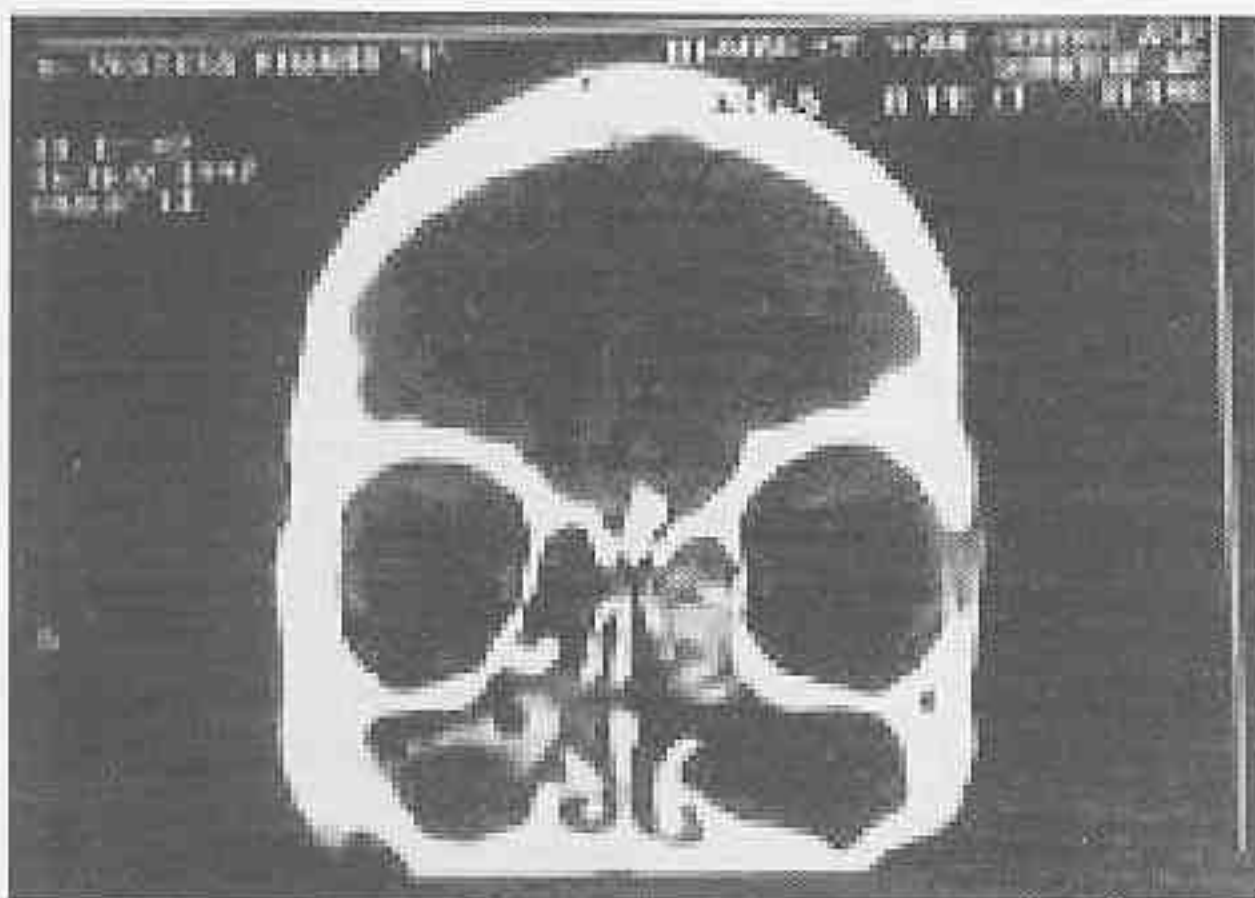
Coronal CT-finding of the same patient six month postop. Some recurrence of disease in the right ethmoidal sinus was cleared by revision surgery.
